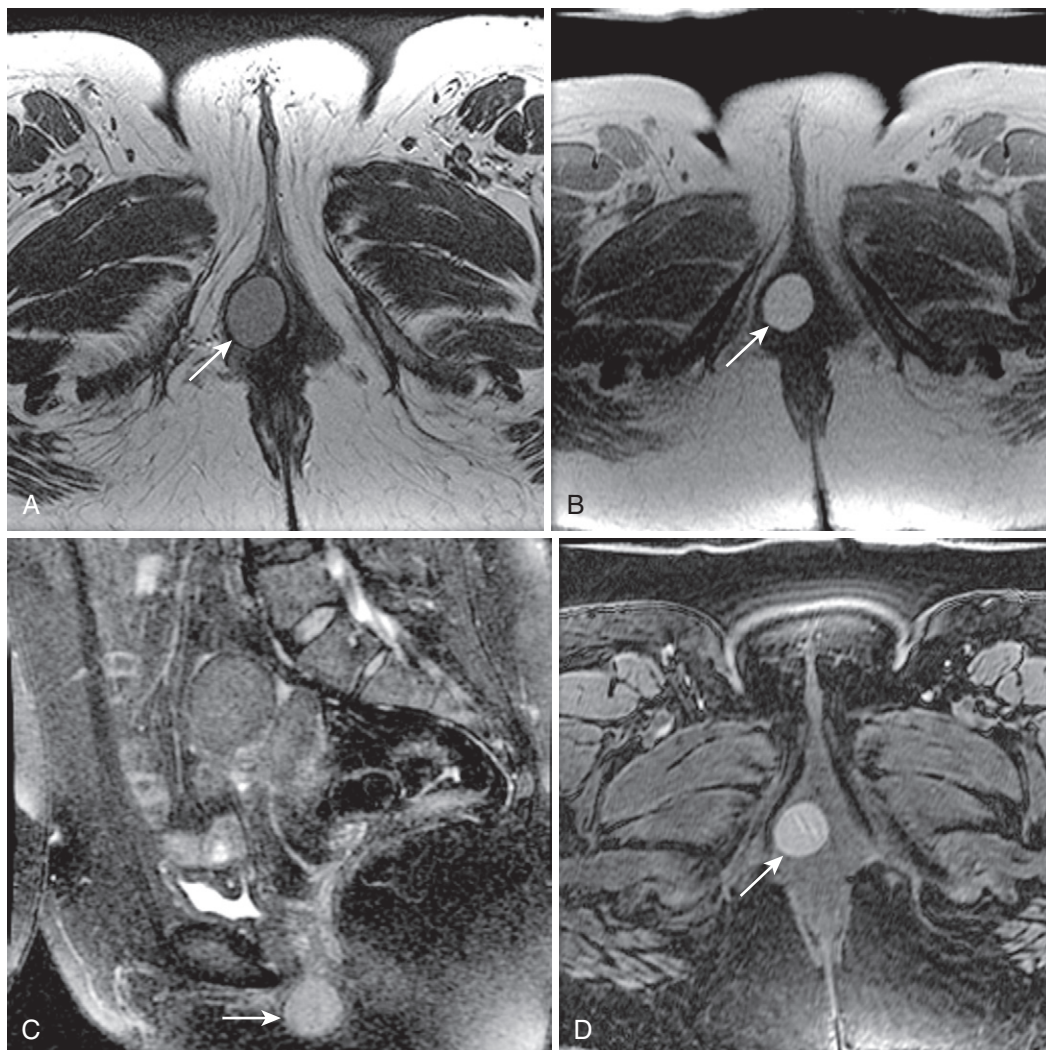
Large complex Bartholin's gland cyst. A large T2 hypointense and T1 hyperintense lesion (*arrow*) on axial T2- (A) and T1-weighted in-phase gradient echo (B) images in the lateral aspect of the vagina with preserved hyperintensity on the corresponding fat-suppressed image (C) is localized to the lower vaginal introitus below the level of the symphysis pubis as seen on the sagittal T2-weighted fat-suppressed image (D).
